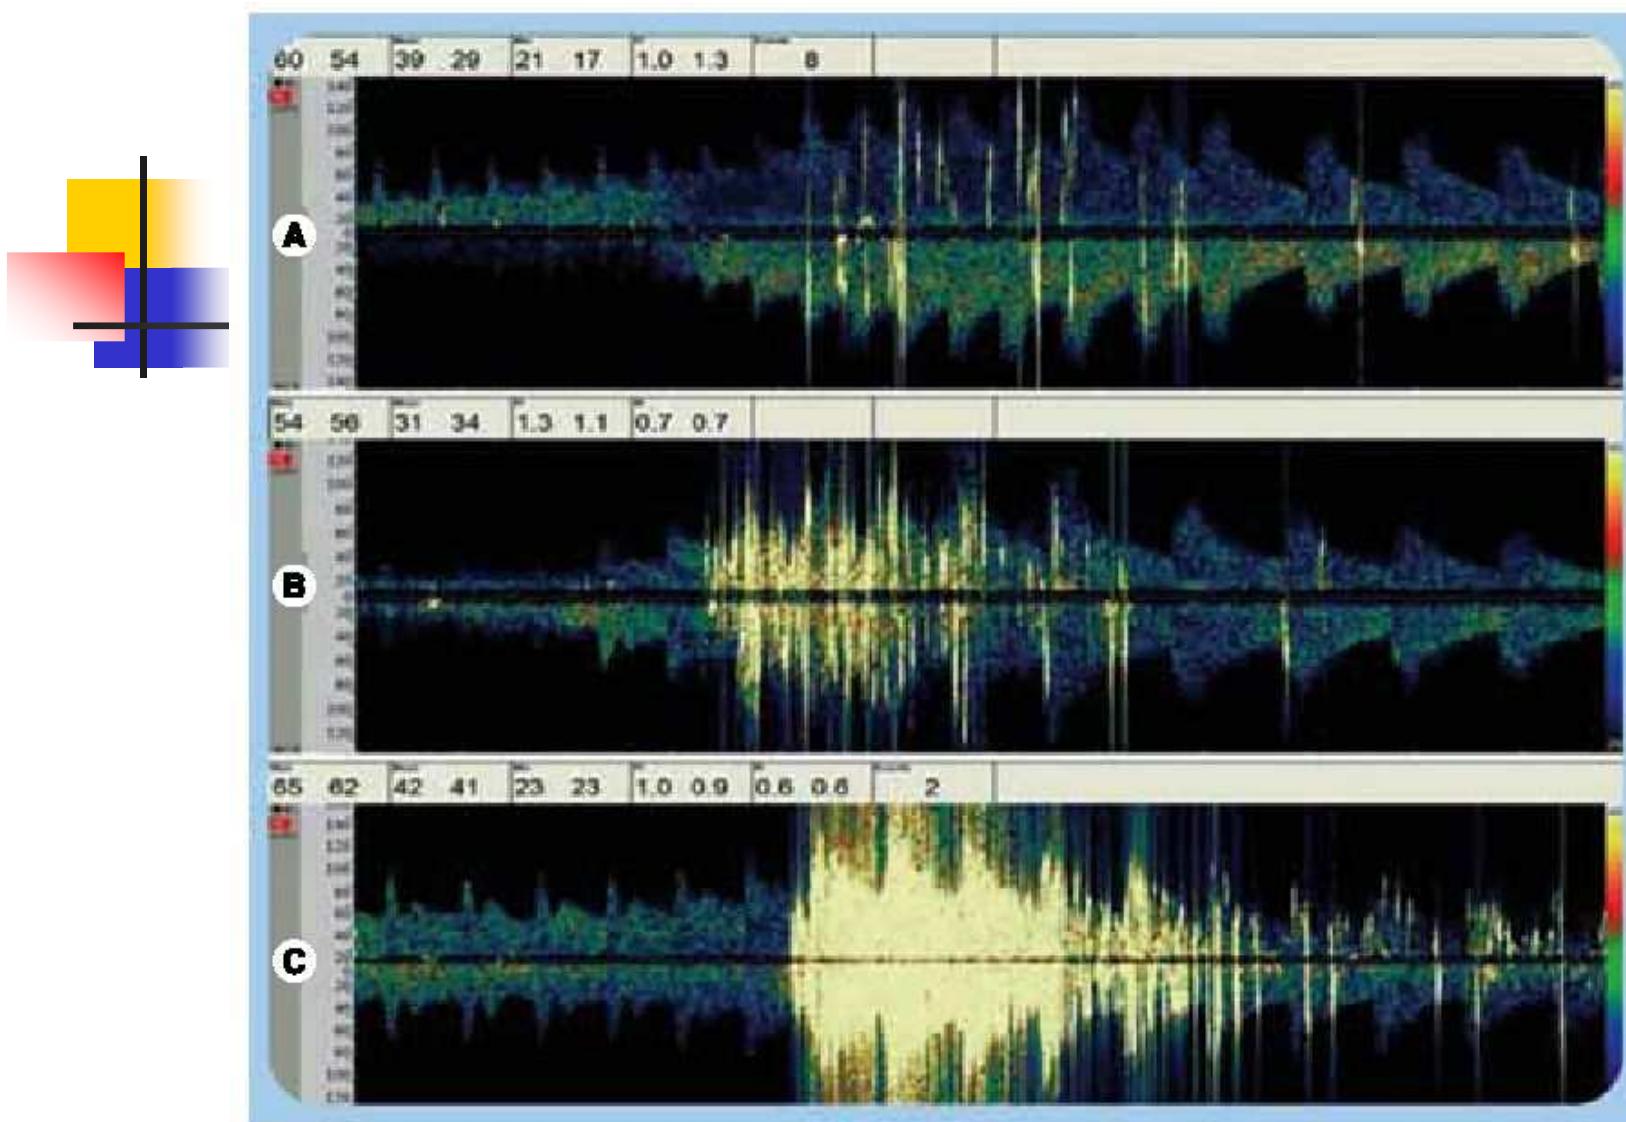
Right-to-left shunt detected by transcranial Doppler sonography with microbubbles in the middle cerebral artery.
